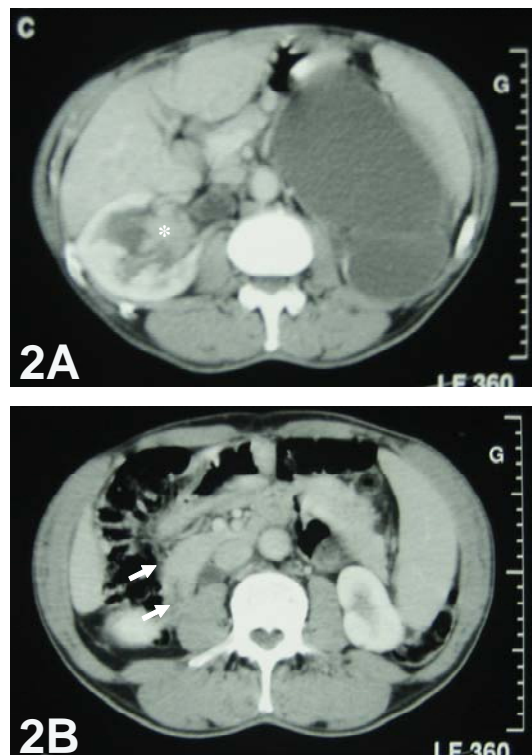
Contrast-enhanced CT scan showing (A) an enhancing soft tissue mass occupying the dilated right renal pelvis and (B) the dilated proximal part of the retrocaval ureter (arrow).
